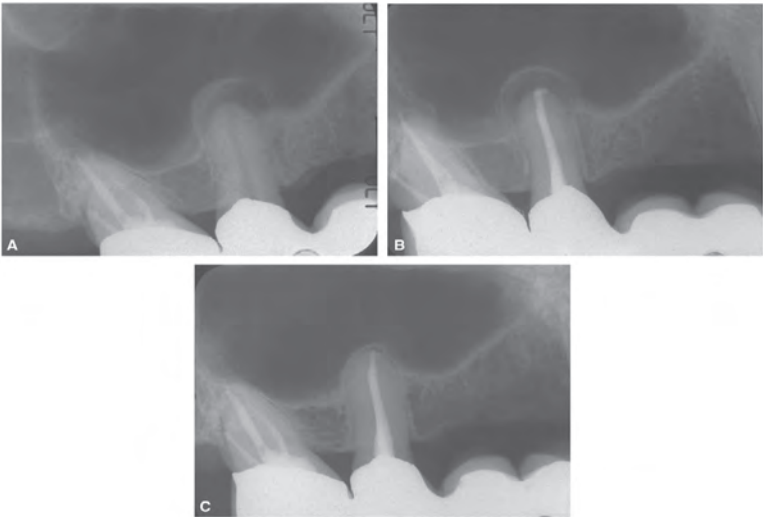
Periapical osteoperiostitis (“halo” lesion). A, Radiograph showing expansive bone formation resulting from displaced periosteum by the periapical infection from pulp necrosis in tooth #4. B, Immediate postoperative radiograph of RCT in tooth #4. C, Follow-up radiograph taken 1 year after RCT demonstrating full resolution of the halo lesion.
